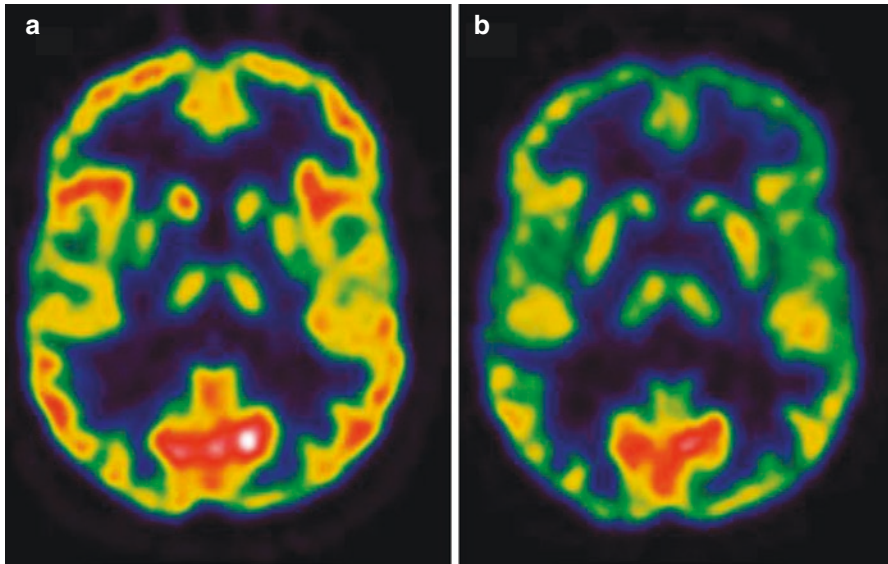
Brain FDG PET/CT of a patient diagnosed with Hodgkin disease. (a) FDG PET/CT at diagnosis, 1 week before commencing the therapy, showing normal FDG uptake throughout the cortex and basal ganglia. (b) Interval FDG PET/CT at 21 days after the first two cycles of chemotherapy (consisting of adriamycin, bleomycin, vinblastine and dacarbazine) which shows a decreased generalised FDG uptake in the brain
